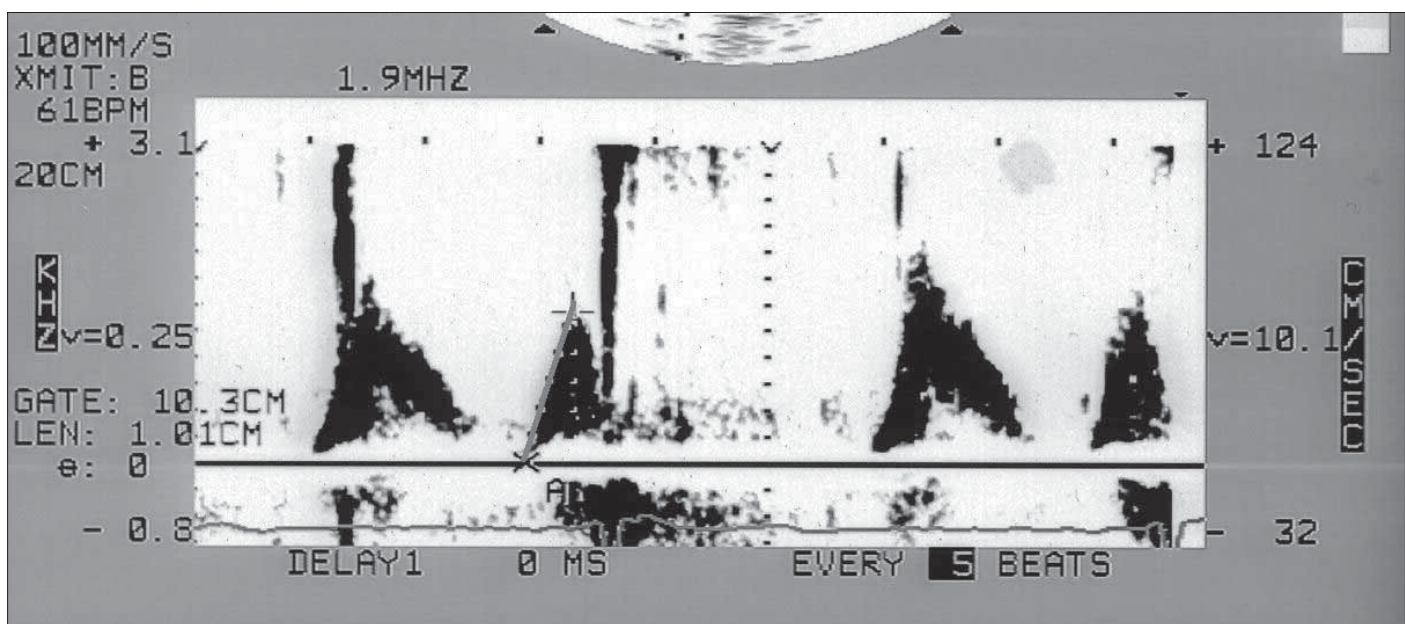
The measurement of the mitral A wave acceleration slope (AWA-slope). The grey line shows the measurement of the AWA-slope (from base to peak of mitral A wave Doppler tracing)
